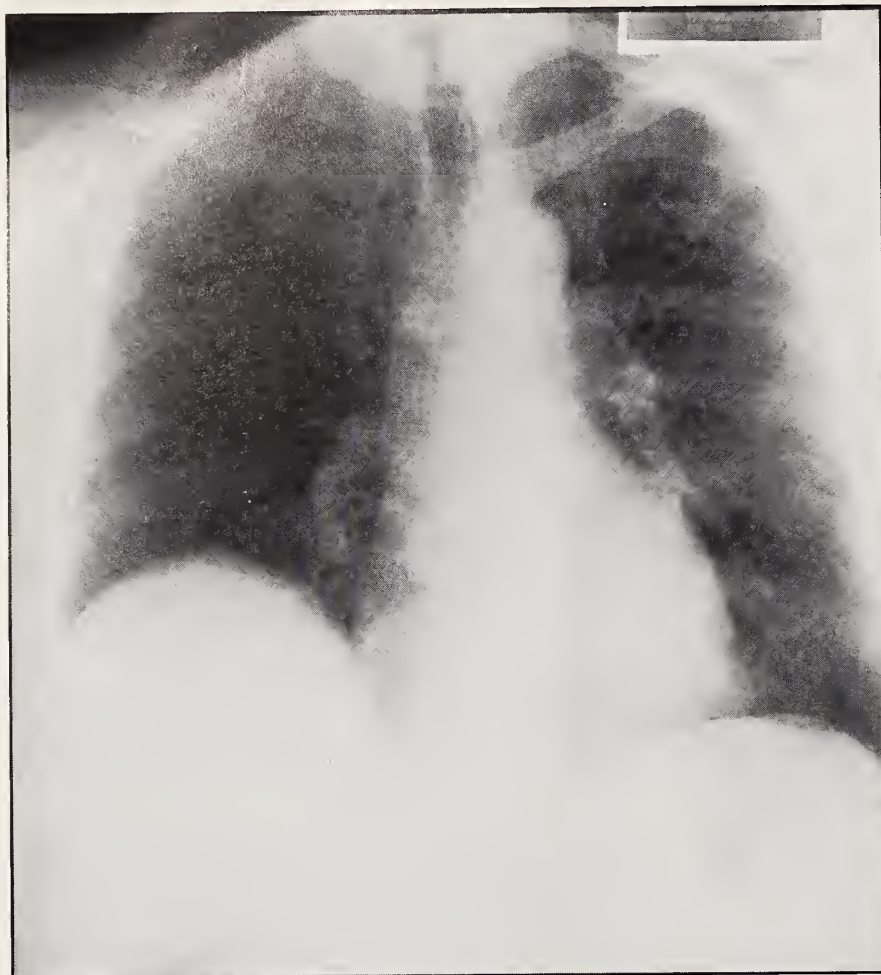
Follow-up chest roentgenogram taken 3 months later which reveals clearing of the infiltrates.
